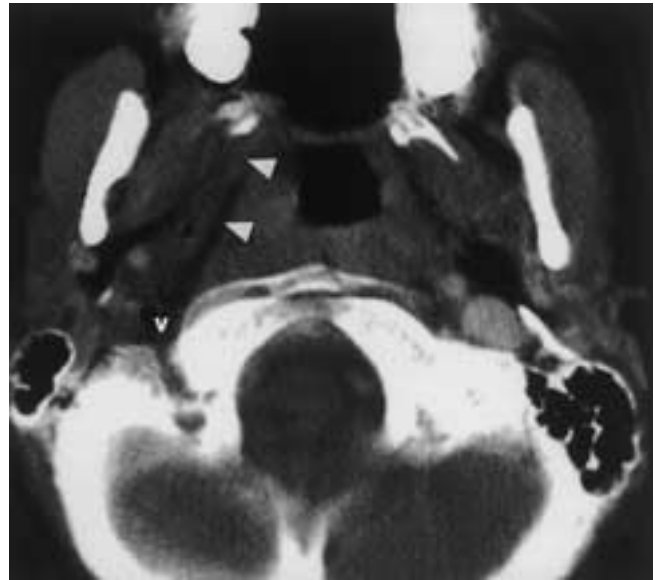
Popsicle-stick injury in a 7-year-old girl. Axial contrast-enhanced CT reveals the low-attenuation retained popsicle stick (*arrowheads*) within the soft tissues lateral to the pharynx, terminating in the expected location of the right internal jugular vein (*v*), which was thrombosed.
